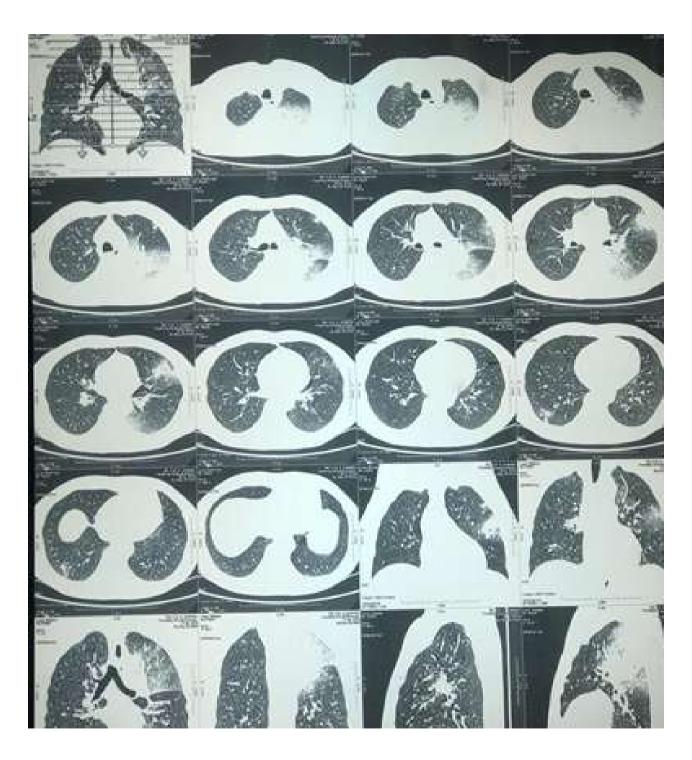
CT Chest showing multifocal consolidative opacities in the lungs
